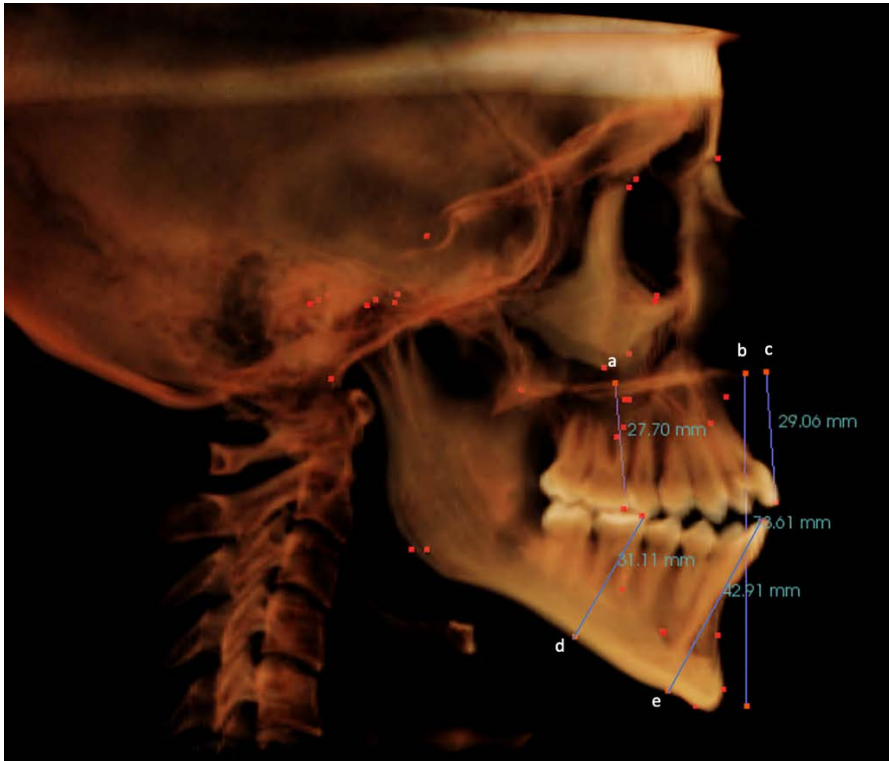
CBCT Measurements. a, U6-PP (mm); b, LFH (ANS-Me); c, U1-PP (mm); d, L6-MP (mm); e, L1-MP (mm).
